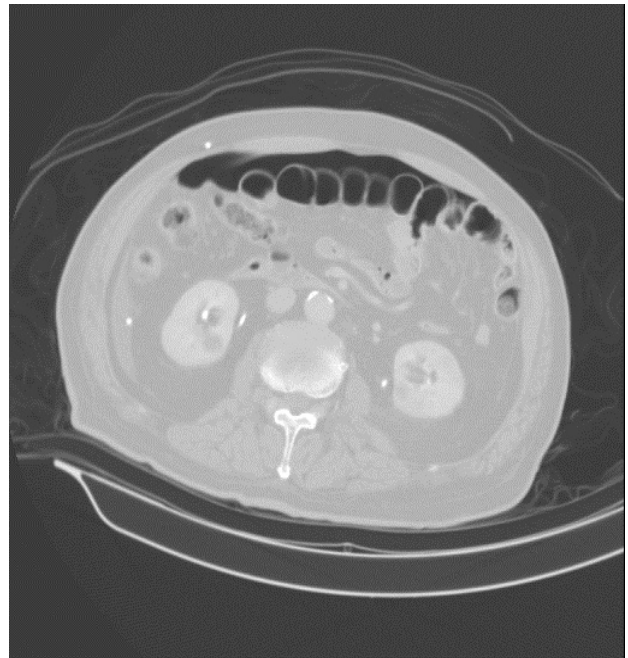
Computed tomography of abdomen confirmed the presence of massive pneumoperitoneum (arrows)
